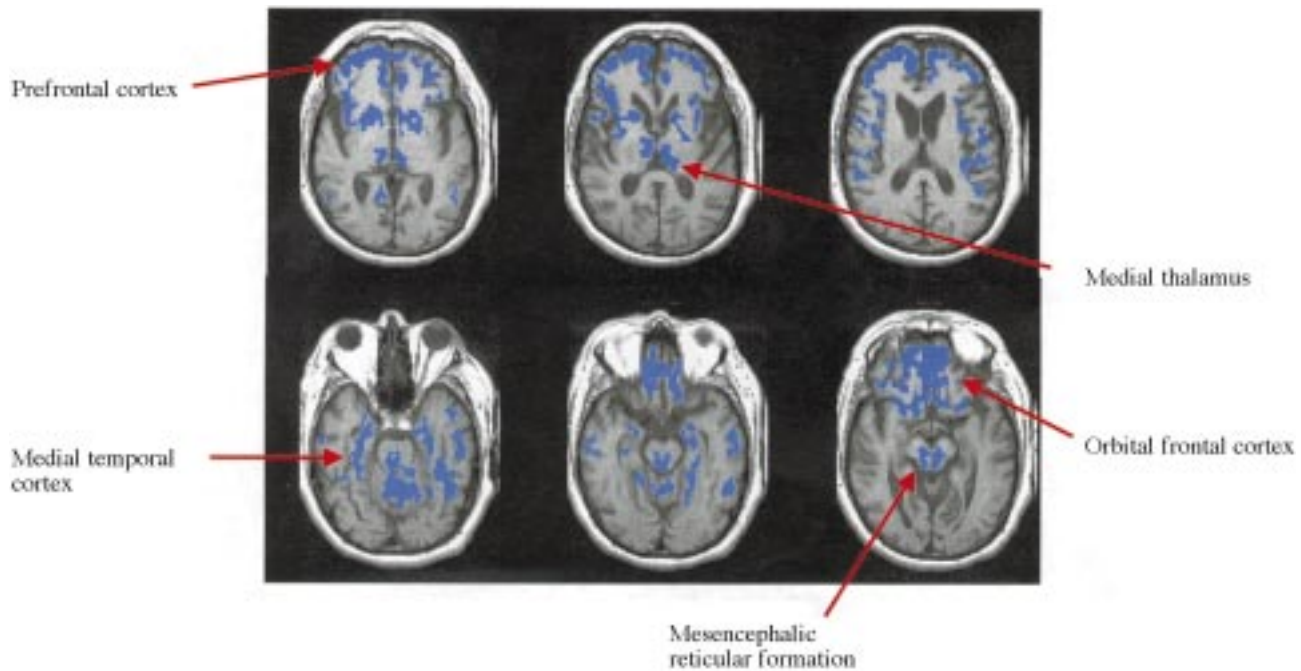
FDG-PET regions of interest for patient 2 are displayed in blue on coregistered MRIs. All areas express  $>30\%$  of normal glucose metabolism to a maximum of  $40\%$  of normal, remaining brain regions demonstrate  $<30\%$  of normal metabolism. Higher metabolism is evident in bilateral prefrontal and orbitofrontal cortices and posterior thalamic and reticular structures.
